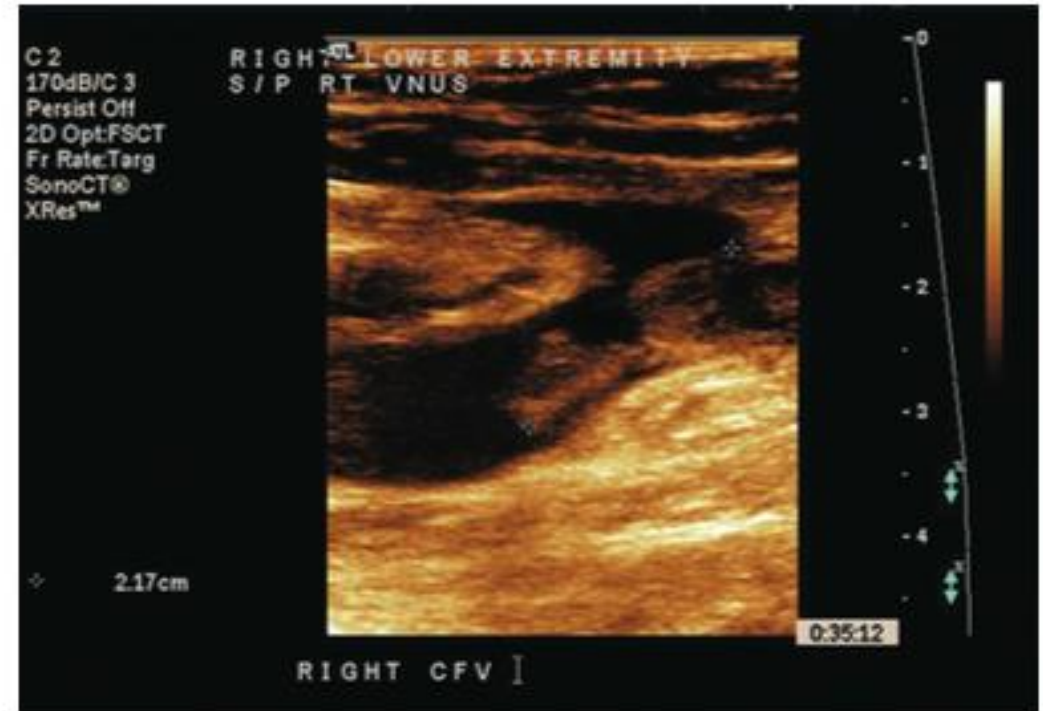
Ultrasound image of thrombophlebitis with free-floating thrombus extending from the great saphenous vein into the femoral vein after radiofrequency ablation of the saphenous vein.
